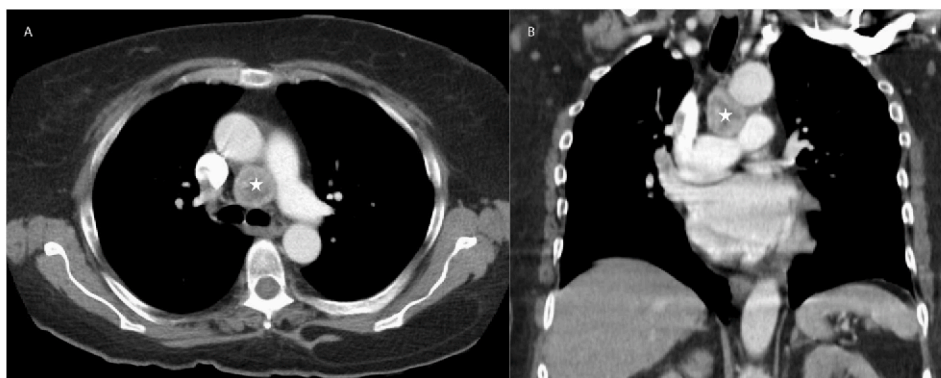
Computed tomography of the chest shows a round heterogeneous lesion (denoted by a star) in the middle mediastinum (A) axial view (B) coronal view.
